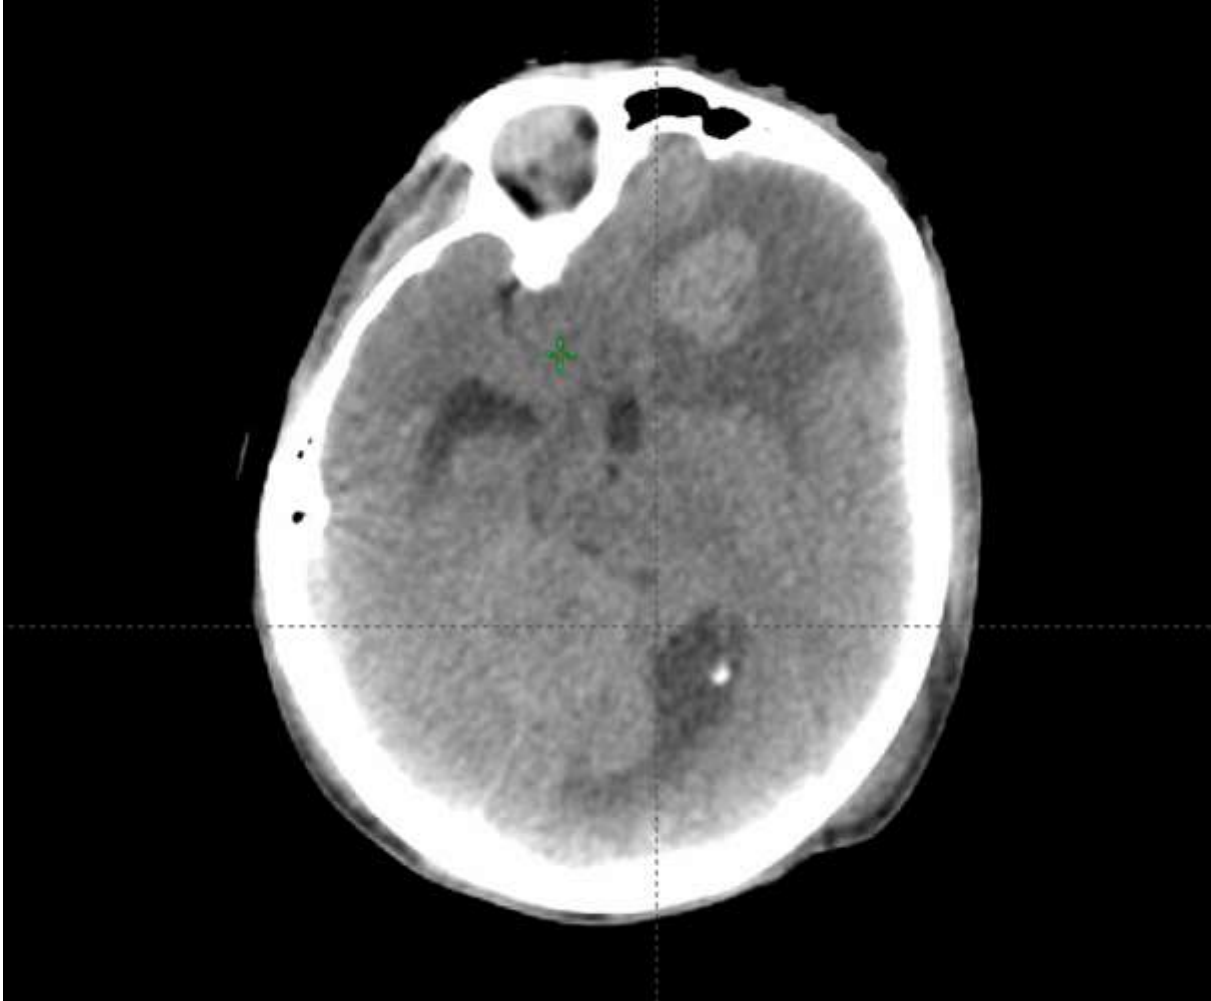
CT image showing brain metastasis.
